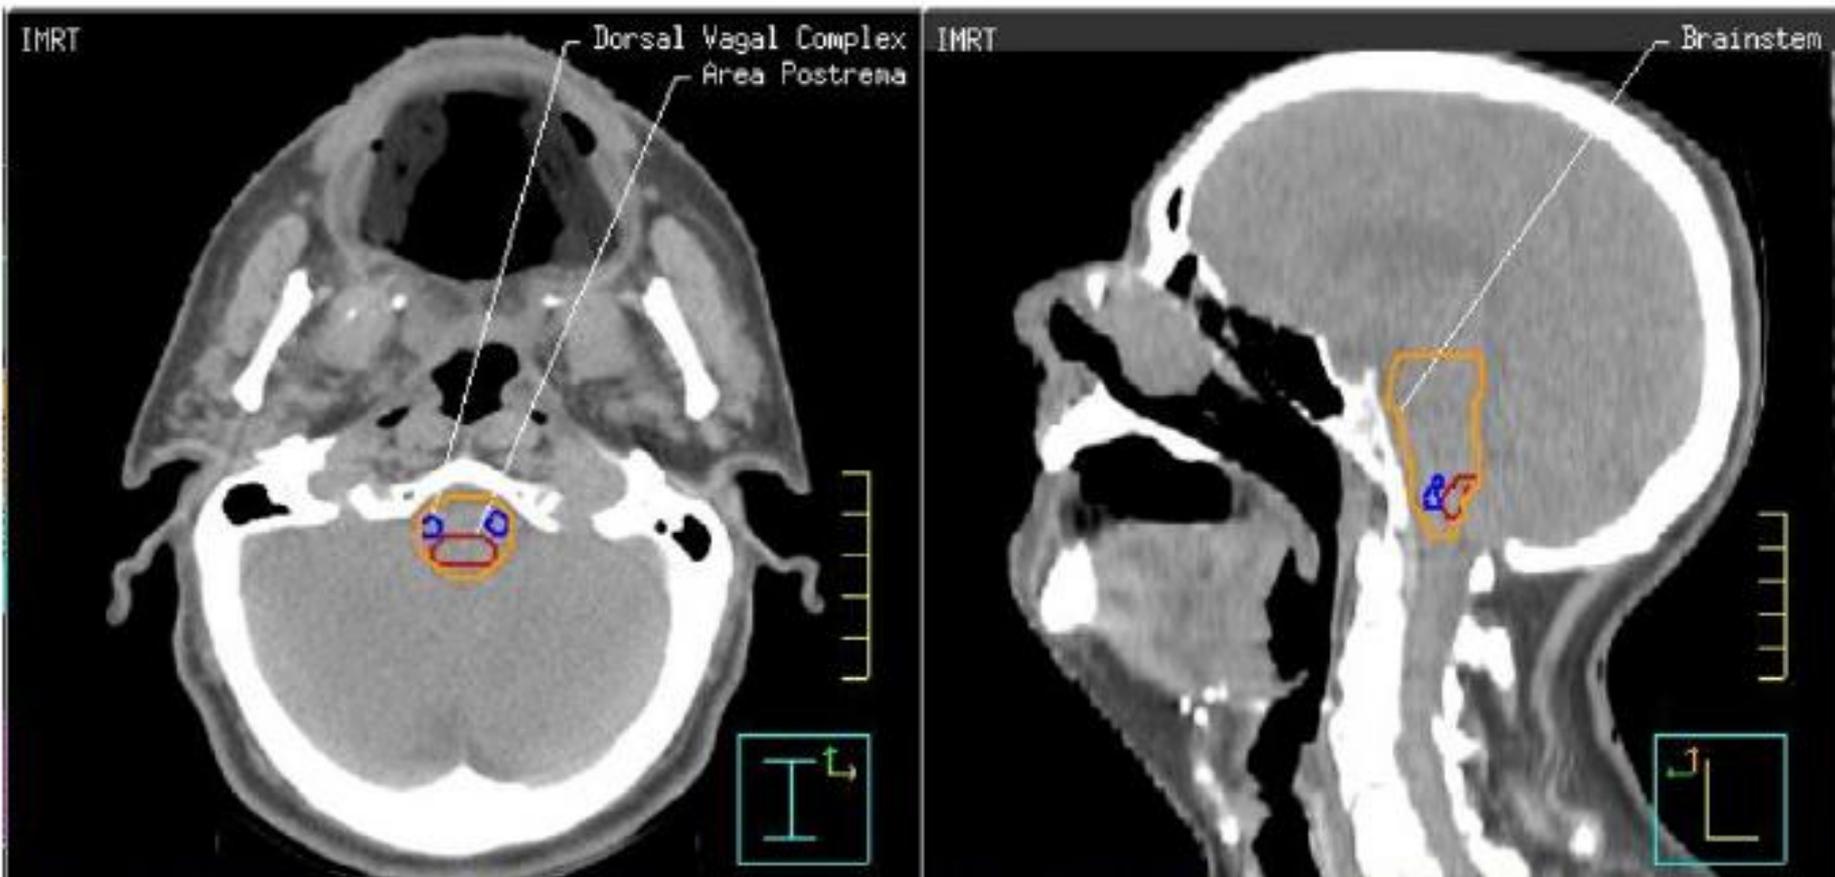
Dorsal vagal complex, area postrema and brainstem delineation on CT.
